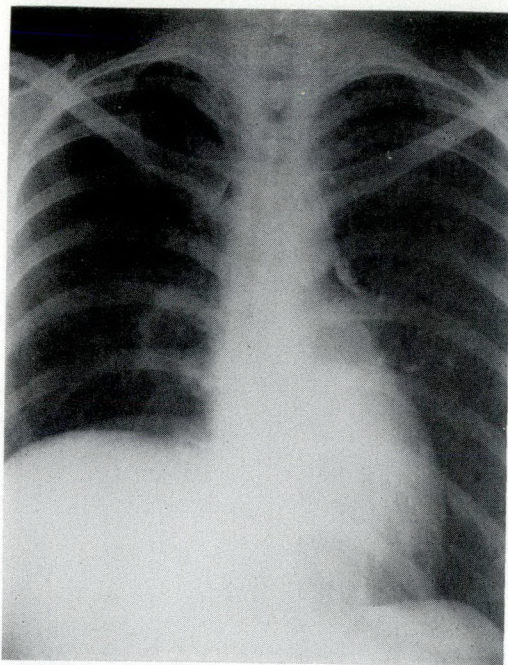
A.O. Chest radiograph August 19, 1940. The right phrenic nerve has been crushed. The disease in the right lung has cleared well.
